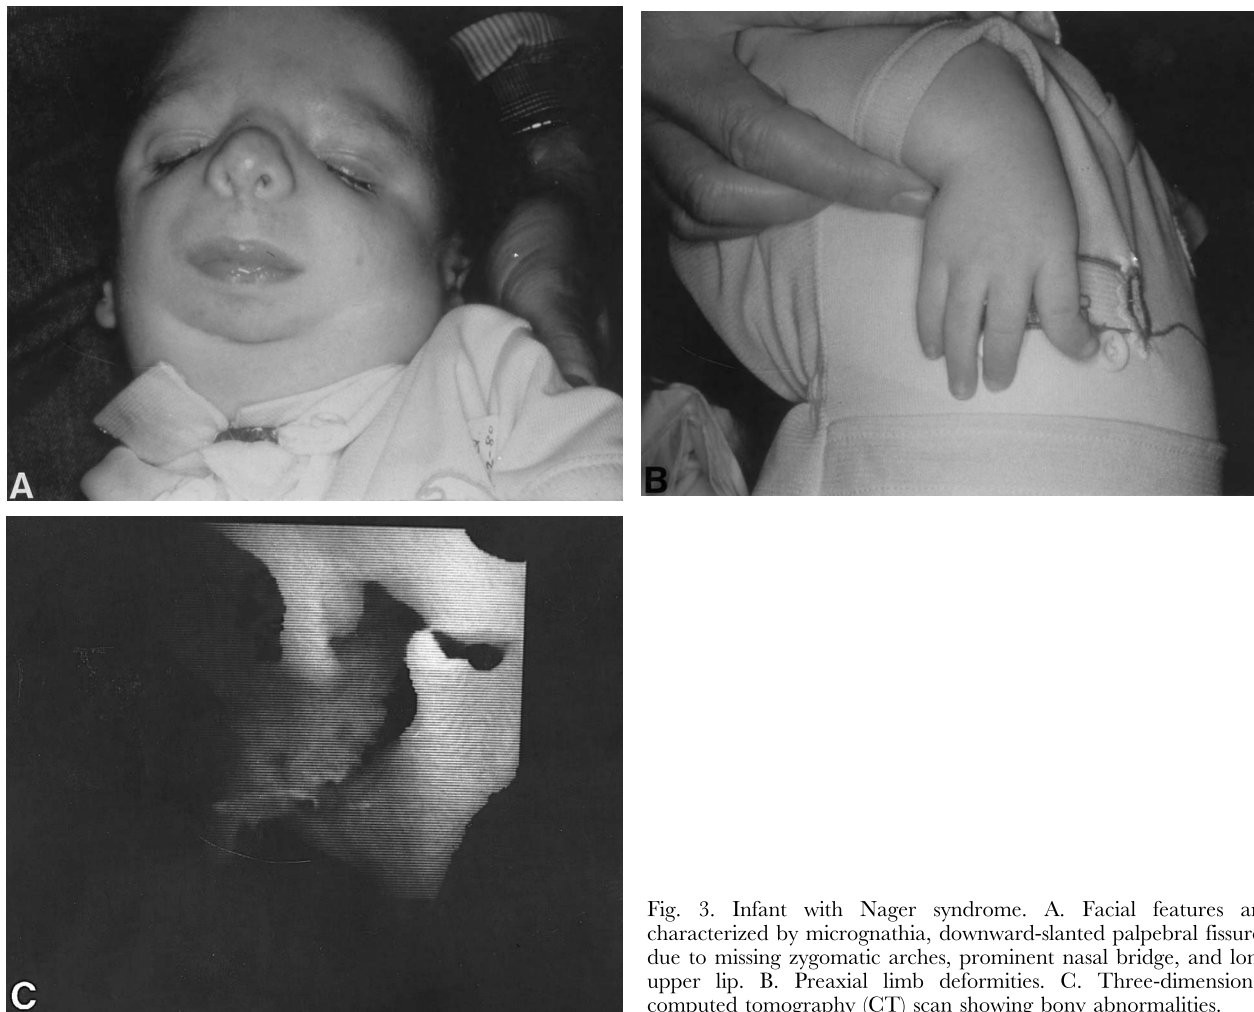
Infant with Nager syndrome. A. Facial features are characterized by micrognathia, downward-slanted palpebral fissures due to missing zygomatic arches, prominent nasal bridge, and long upper lip. B. Preaxial limb deformities. C. Three-dimensional computed tomography (CT) scan showing bony abnormalities.
